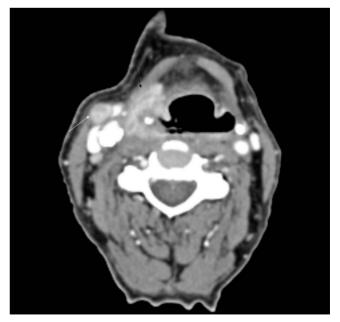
Axial contrast-enhanced CT showing right pyriform fossa tumour just extending into the paraglottic space and extralaryngeal soft tissues (black arrow) with associated metastatic level 3 node (white arrow).
